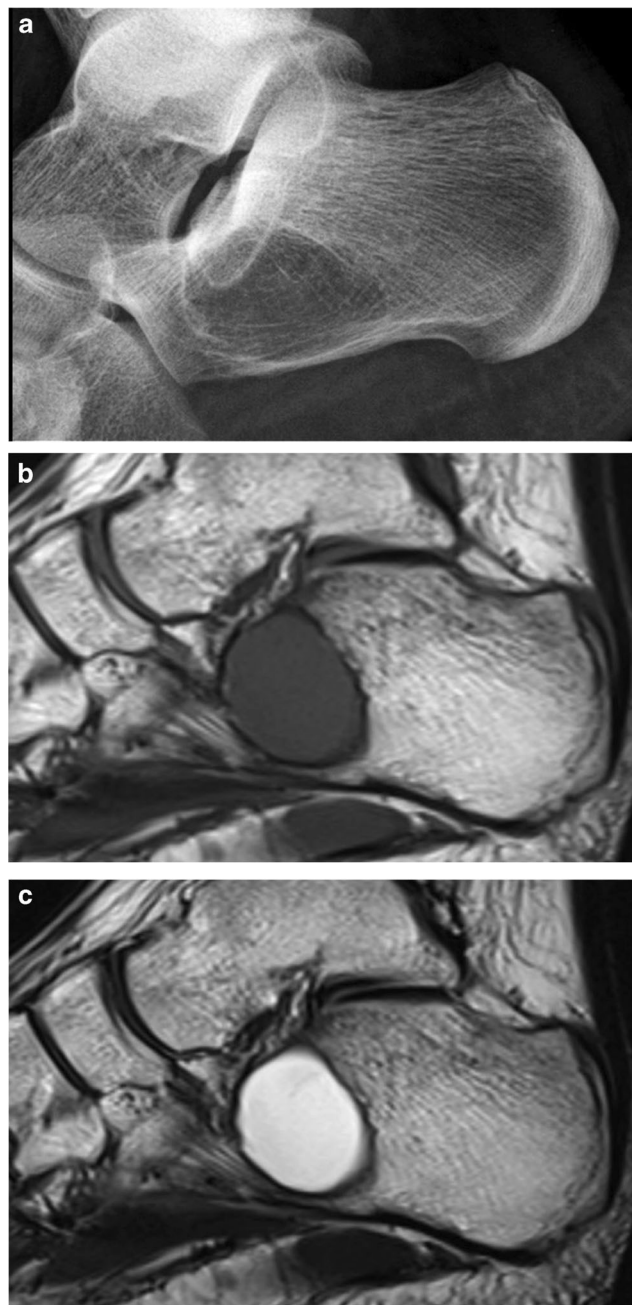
Calcaneal cyst in a 17-year-old male. Radiography (a) shows a defect in the same area as a pseudo-cyst. The defect contains fluid that has low signal intensity on T1-weighted MRI (b) and high signal intensity on T2 weighting (c)
